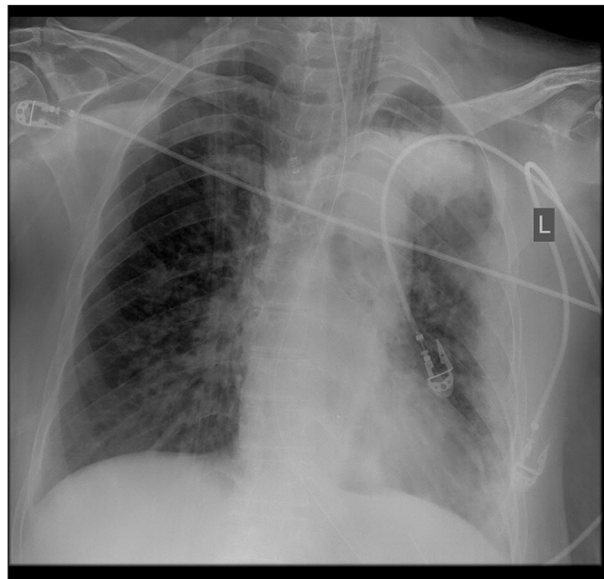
Chest x-ray on admission. Diffuse bilateral pulmonary infiltrates with a predominance to the left upper lobe.
